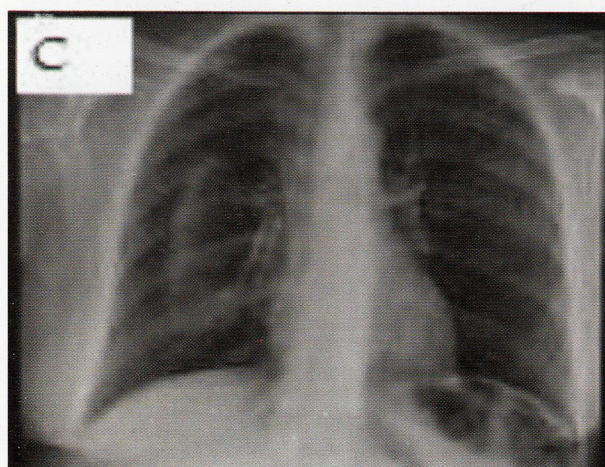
(C) Two years follow-up X-ray chest showing normal lung fields and methylmethacrylate cement shadow. Fig-1(D) Two years follow-up post operative C/T scan showing no recurrence.
